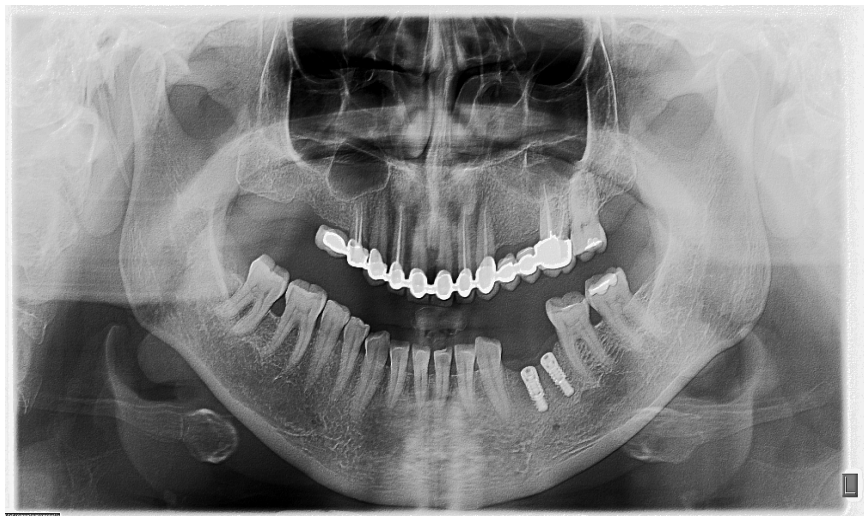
Radiographic evaluation of two adjacent implants 3 months after second surgical placement.
